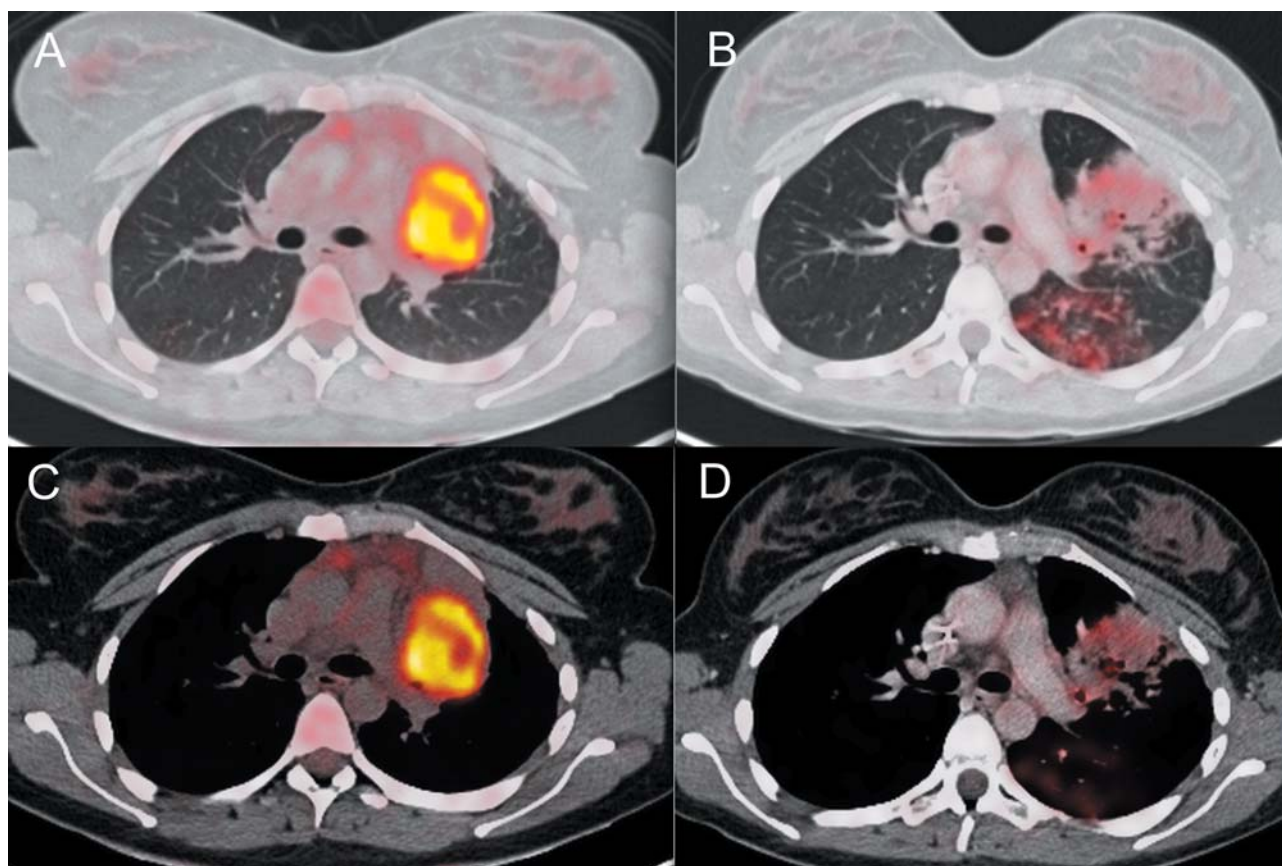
Positron-emission tomography with computed tomography scan (PET-CT) pulmonary and mediastinal window. A, C. Pretreatment scan; B, D: Post-treatment scan. Significant radiological and metabolic partial mass response. Disappearance of the intraluminal image.
